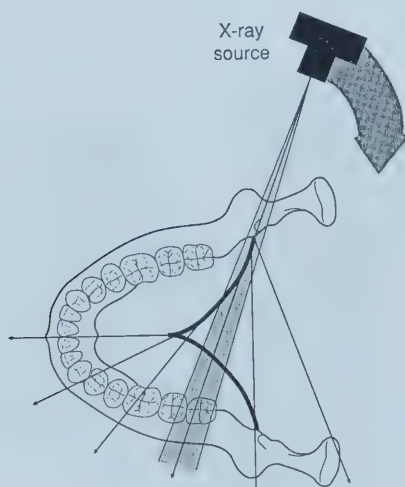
Rotation Centers in Panoramic Radiography. The dark line shows a continuously moving center of rotation. Note that the center of rotation is near the lingual surface of the right side of the mandible when the left TMJ is imaged. As the x-ray source moves behind the patient's neck, the rotation center moves anteriorly towards the sagittal plane and ends just lingual the mandibular symphysis. The arc is reversed as the opposite side of the patient is imaged. (From Goaz PW: White SC 1994; 12: 244)
